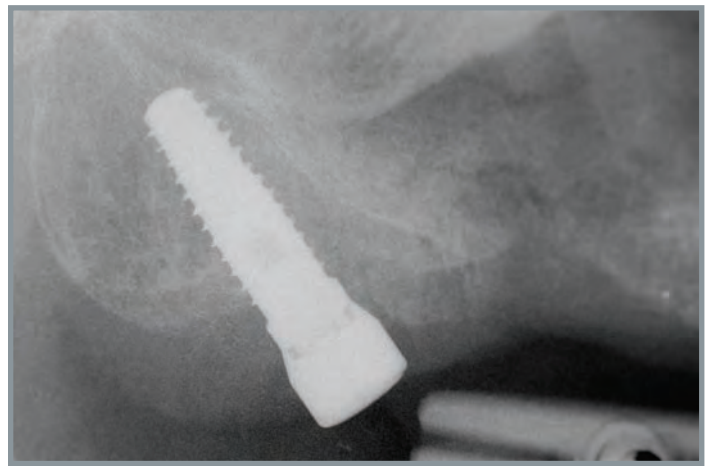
Periapical intraoperative radiograph. Implant placed in maxillary tuberosity.
